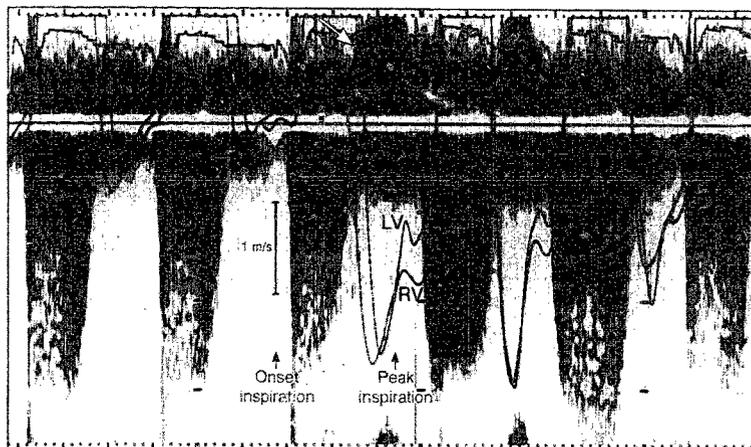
Simultaneous high fidelity manometer tracing of right (RV) and left ventricular (LV) pressures with continuous wave Doppler echocardiographic recording of tricuspid regurgitation from two patients (A and B) with restrictive cardiomyopathy. There is a decrease in right ventricular systolic pressure and a decrease in peak velocity and duration of the tricuspid regurgitation signal at peak inspiration. In a third patient with restrictive cardiomyopathy (C), there are simultaneous tracings of right ventricular and right atrial (RA) pressures with the continuous wave Doppler recording of tricuspid regurgitation. Because of the decrease in right ventricular pressure with little change in right atrial pressure during inspiration, there is an overall decrease in the right ventricular-right atrial pressure gradient and a decrease in the tricuspid regurgitant velocity.
